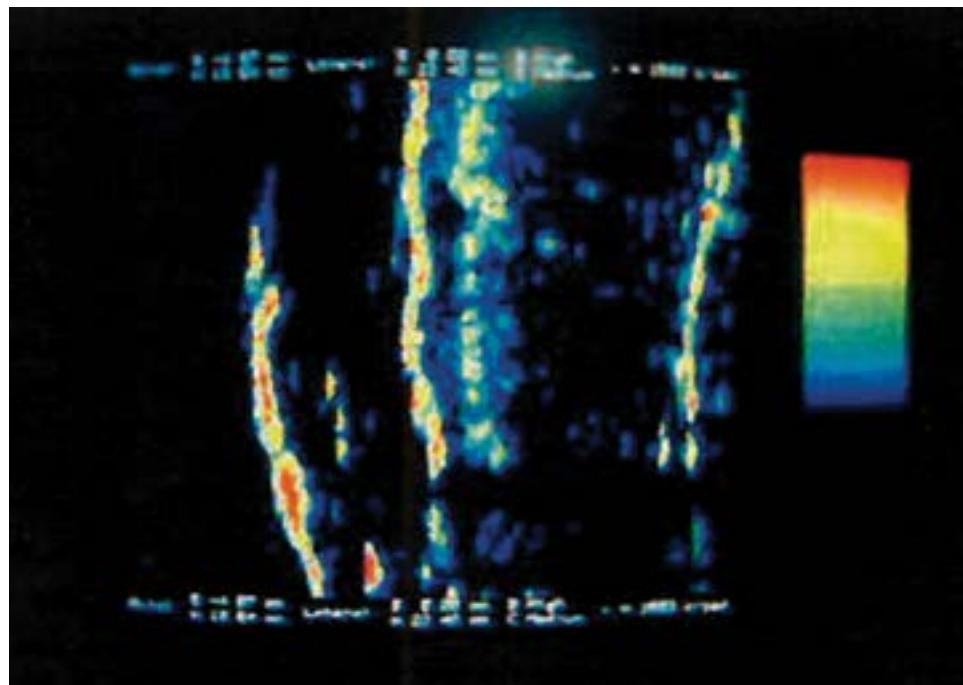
The ultrasound showed a reduced thickness - 0,84 mm
